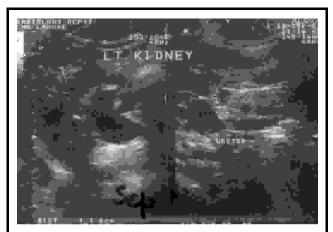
Patient with severe left ureteric colic, ultrasound shows left ureteric calculus with hydronephrosis and hydroureter confirmed on ct kub.
